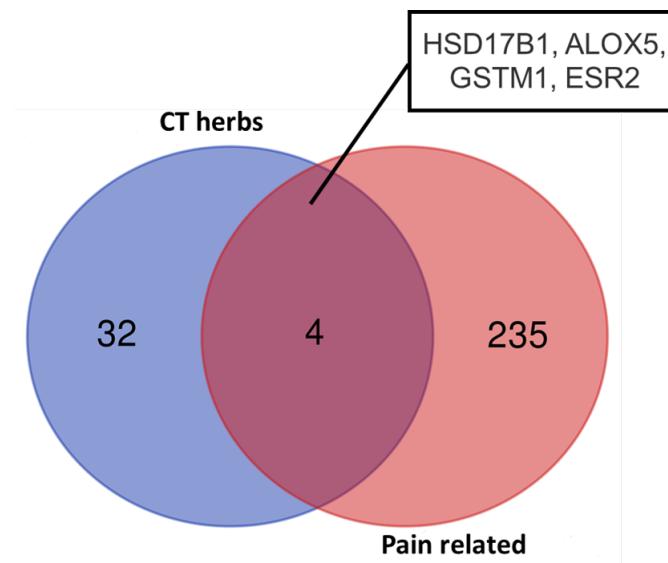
Overlap analysis between CT target genes and pain-related dysmenorrhea
